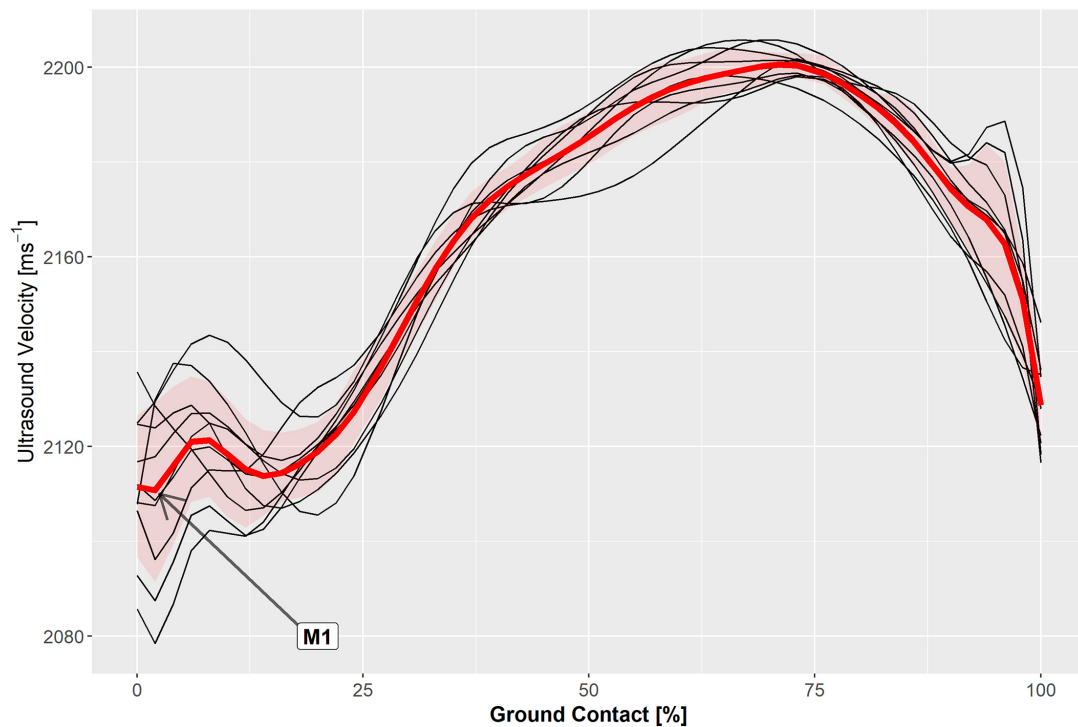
Axial velocity of ultrasound measured in the Achilles tendon during the ground contact phase of ten hop cycles (black traces) and the ensemble average (red trace) in a representative participant.
